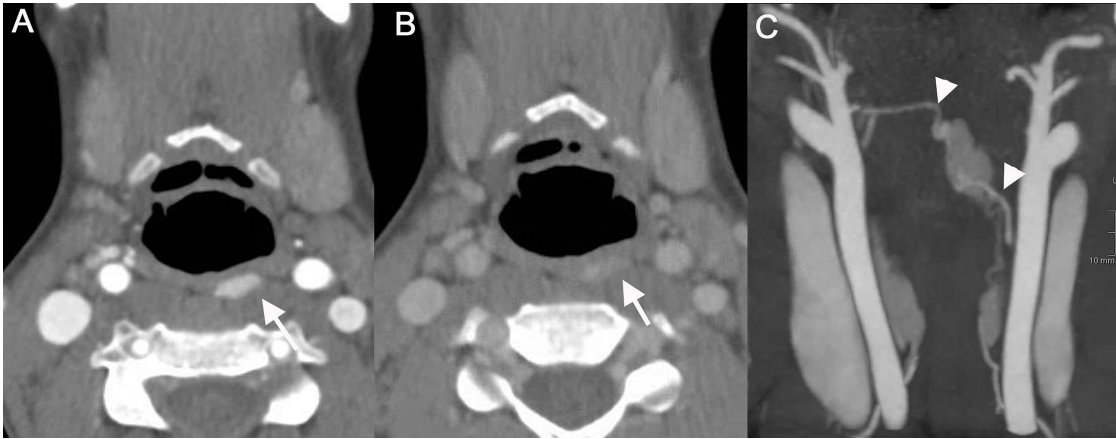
Contrast-enhanced CT imaging was performed with a limited field of view of the area of suspected midline retropharyngeal parathyroid adenoma with arterial angiographic and 40-s delayed venous phases confirming arterial phase enhancement of 293 Hounsfield units (A, arrow) and rapid wash-out to 127 Hounsfield units (B, arrow). Coronal reconstructions from the 0.625 mm source axial arterial phase sequence better defined the bilateral vascular structures (C, arrowheads) for surgical planning.
